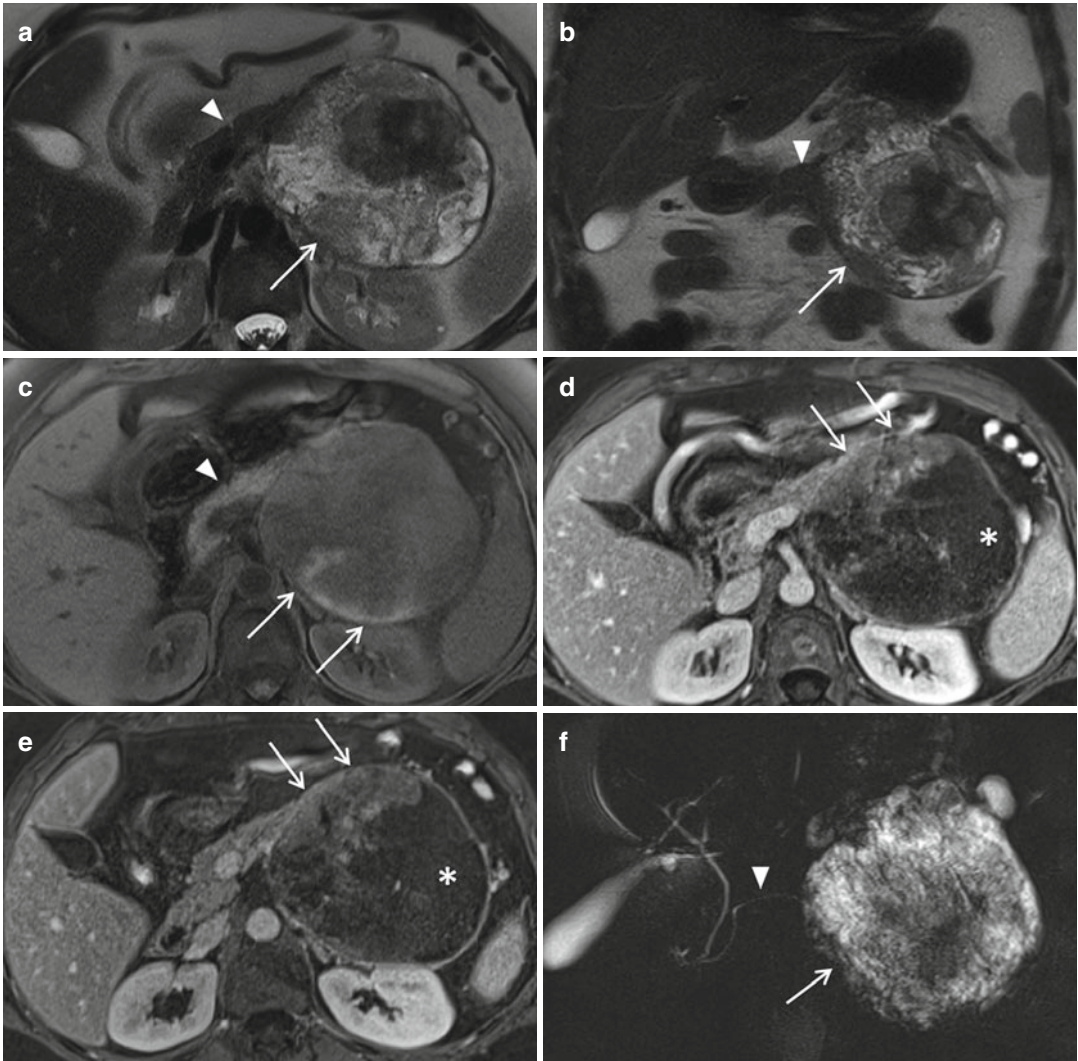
A 43-year-old female patient with solid pseudo-papillary neoplasm (SPN). (a, b) Axial (a) and coronal (b) T2-weighted images: a cystic lesion (*arrow*) is present in the tail of the pancreas; it is heterogeneously hyperintense compared to the surrounding pancreatic parenchyma (*arrowhead*). (c) Axial T1-weighted GRE image with fat saturation: the neoplasm is hypointense compared to the surrounding pancreatic parenchyma (*arrowhead*); hyperintense areas correspond to intralesional hemorrhage
